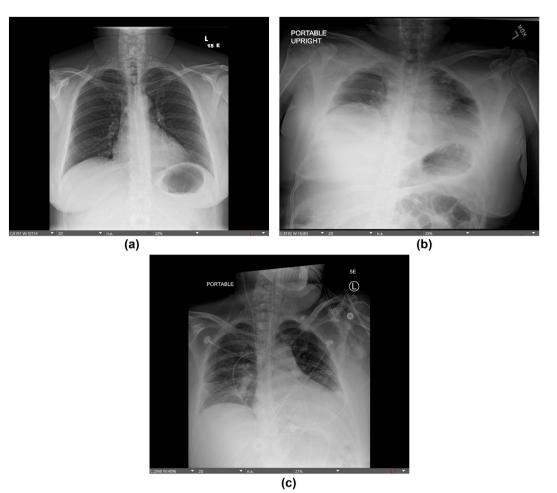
Chest x-ray a. preoperatively, b. on admission, c. after revision of abdominoplasty.
